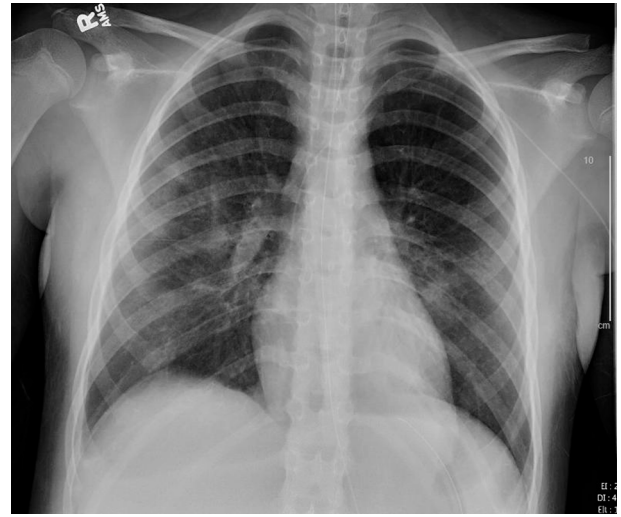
Chest X-ray, anteroposterior (AP) view after 2 days of remdesivir therapy (hospital day 10).
